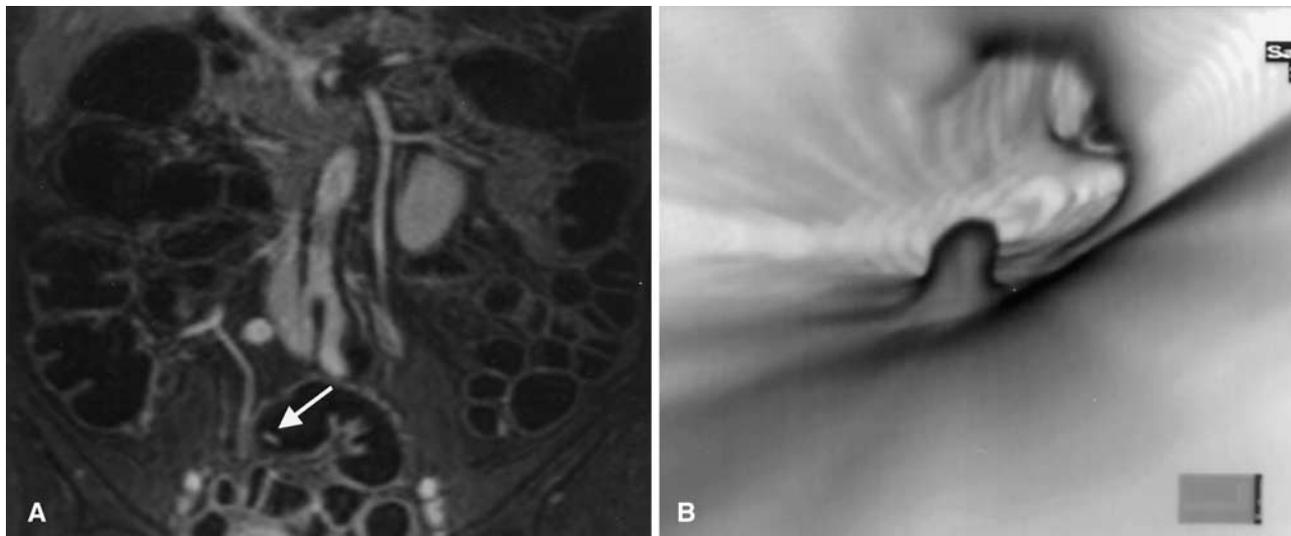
A Coronal reformatted image of a 3D T1-weighted data set acquired 75 s after intravenous contrast injection shows a 10-mm lesion in the sigmoid colon with high contrast enhancement (*arrow*) and was rated as a colorectal
